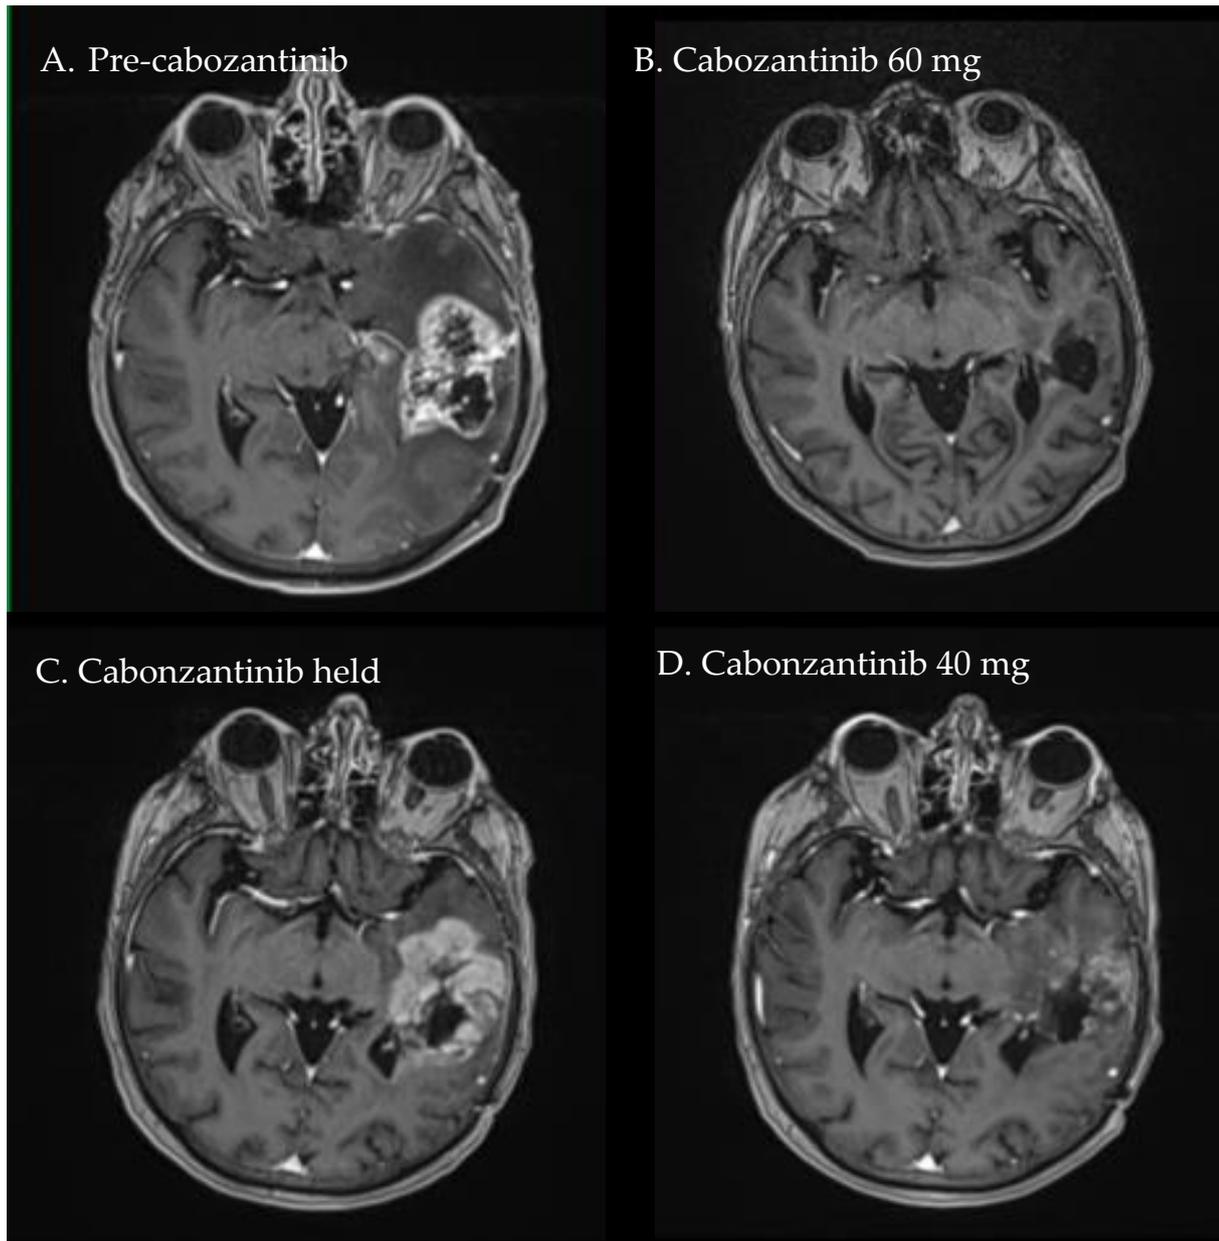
(A) Baseline MRI at progression. (B) MRI at four weeks following cabozantinib, revealing complete response. (C) After four weeks of holding cabozantinib, MRI revealing progression. (D) After four weeks of dose-reduced cabozantinib, MRI revealing partial response.
